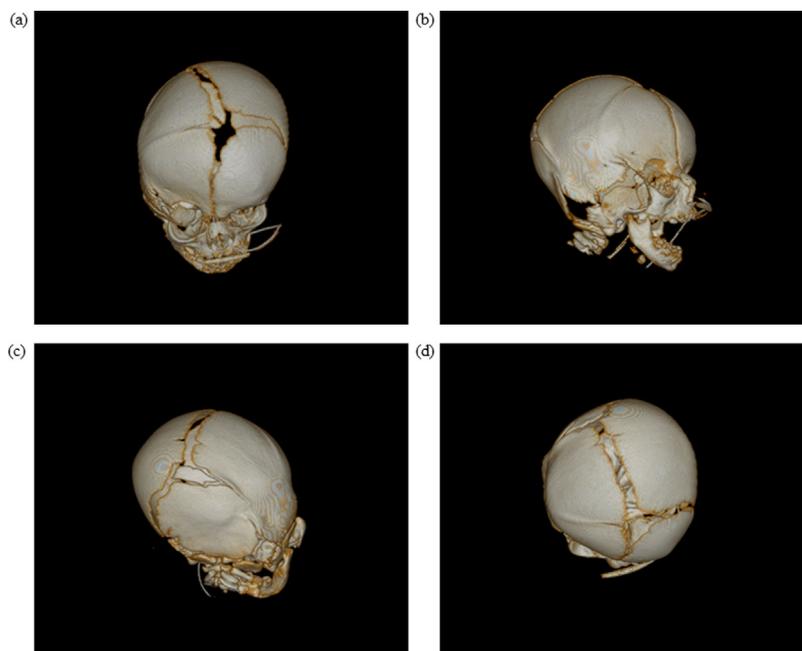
(a–d) Computed tomography of the skull. The four images are 3D reconstructions of the skull viewed from various positions and demonstrate right coronal, right lambdoid, and squamous temporal craniosynostosis with gross deformity of the calvarium and right orbital cavity [Color figure can be viewed at wileyonlinelibrary.com].
